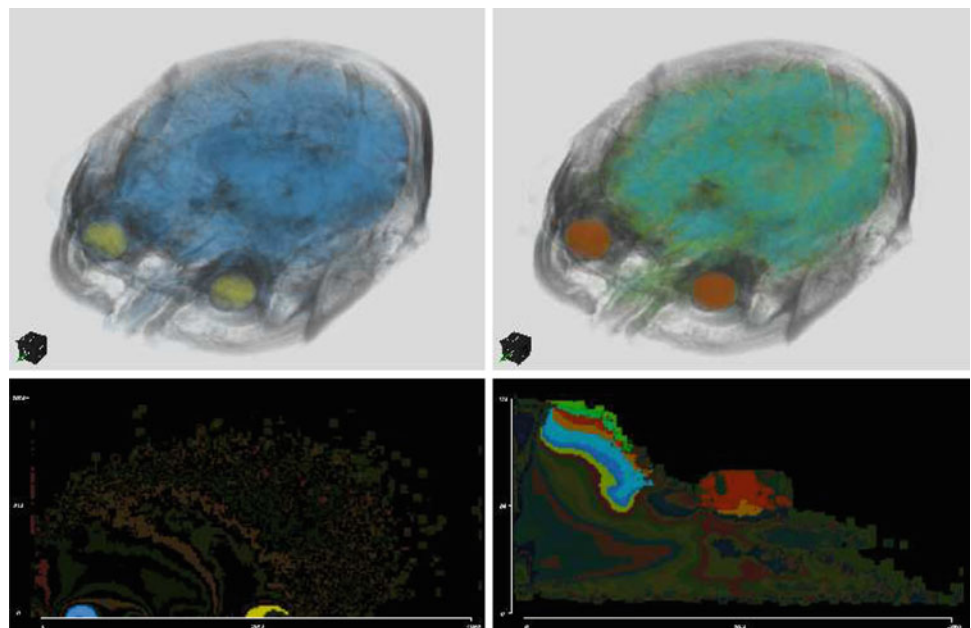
MRI data set of a head with two structures highlighted—the eyes and the brain. In the IGM histogram (*left*) they are represented by small clusters located at the bottom of the 2D histogram. The SSE histogram (*right*) has a more intuitive meaning, and brain and eyes are easy to select, being the largest structures in their corresponding gray value ranges
